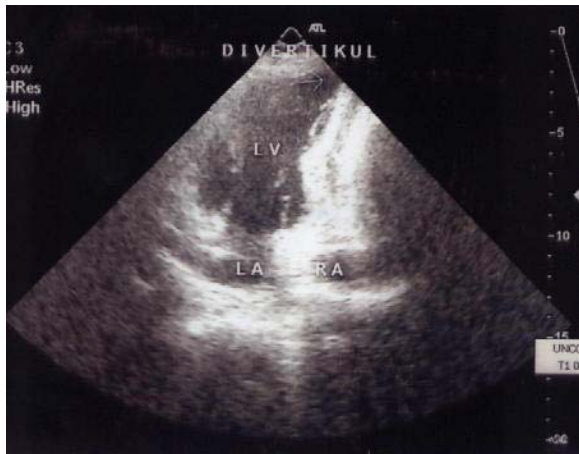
The echocardiogram.
